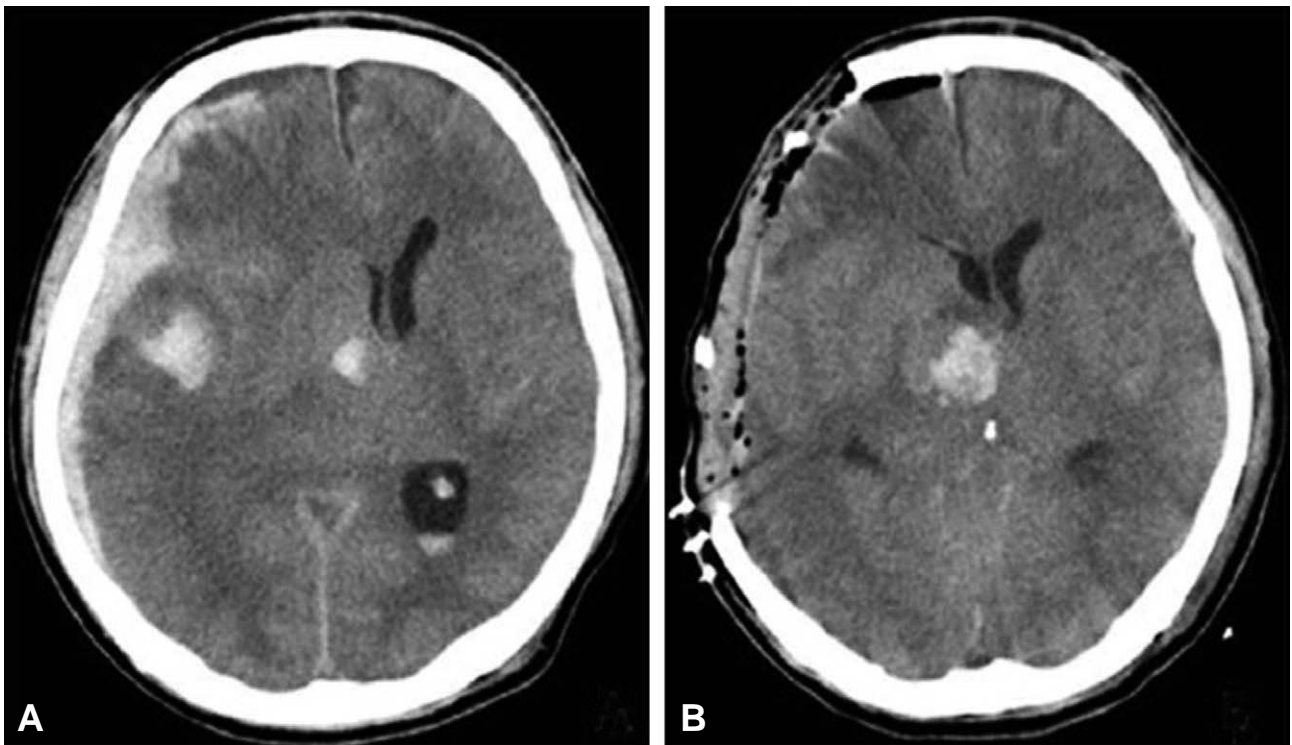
Brain CT showing increased subdural hemorrhage, aggravated mid line shifting (A), after craniectomy, midline shift is decreased and subdural and intracranial hemorrhage is reduced (B).
